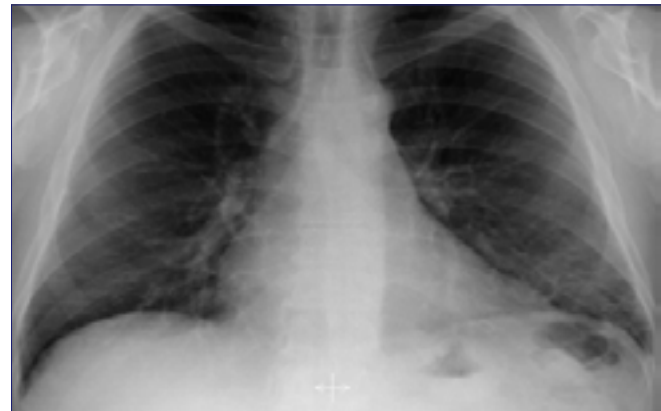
Imaging of lungs at presentation. a) CXR showing left basal reticulation. b) CT scan showing interstitial lung disease with areas of ground glass change.
